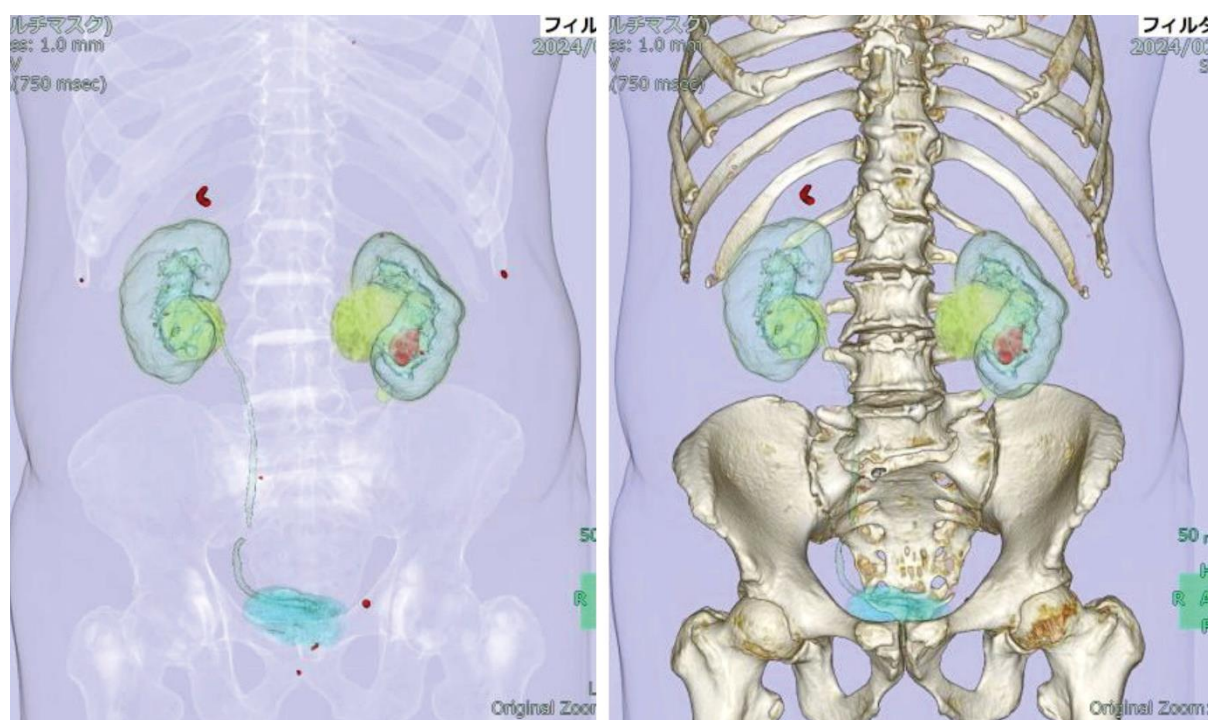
Abdominal CT Reconstruction (Coronal Section)
